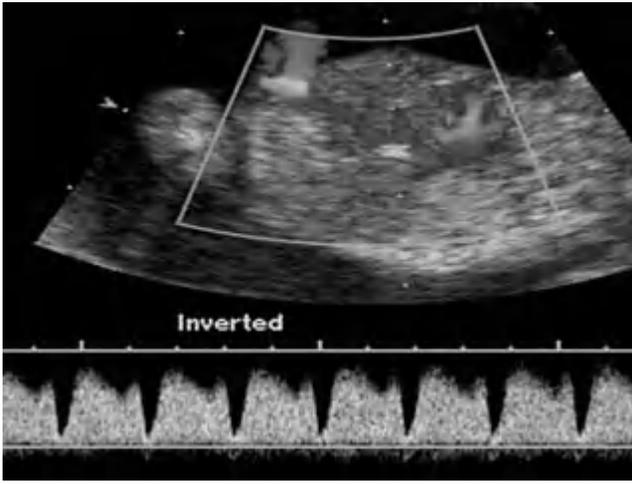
Ductus venosus flow velocity waveform in a normal 13-week fetus. The Doppler gate is placed in the ductus venosus between the umbilical venous sinus and the inferior vena cava. Note that there is triphasic pulsatile flow with constant forward flow. The troughs of flow during the atrial contraction also demonstrate forward flow. (From Malone and D'Alton, 2003.)
